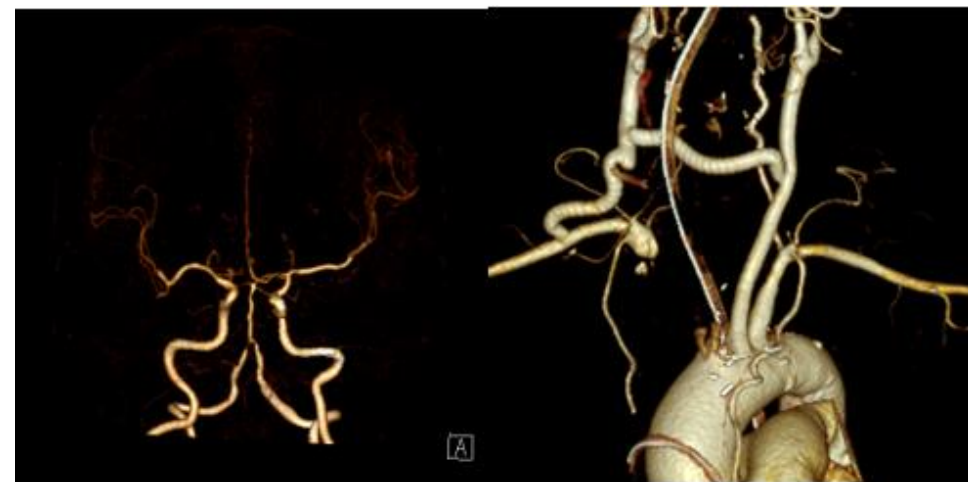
Pre-operative Carotid CT and Postoperative LCCA-RCCA-RSCA CT
